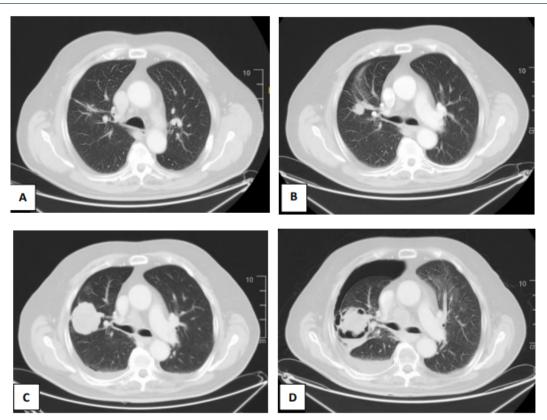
CT scans of the pulmonar mass. (A) spiculated left lung nodule at baseline. (B) Proggressive disease after 13 months of response to Osimertinib. (C) Proggresion of a Solid mass after Osimertinib and Capmatinib treatment. (D) massive cavitation with secondary hydroneumothorax during Gefitinib Treatment.
